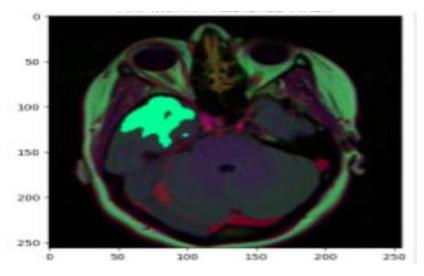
Brain MRI with predicted mask
